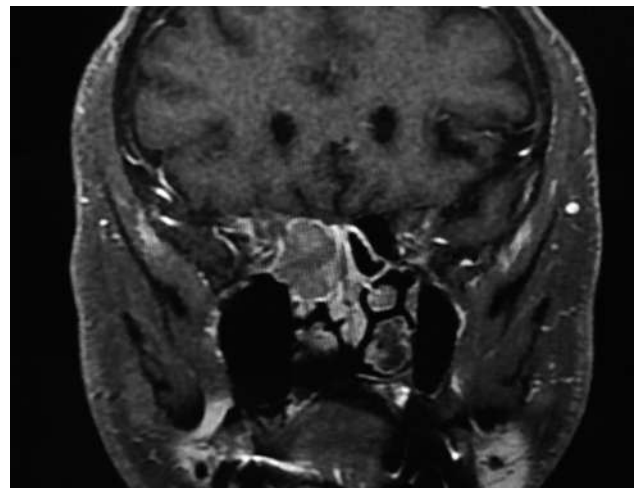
T1-weighted MRI in the coronal section with gadolinium showing lesion in the nasal cavity.
